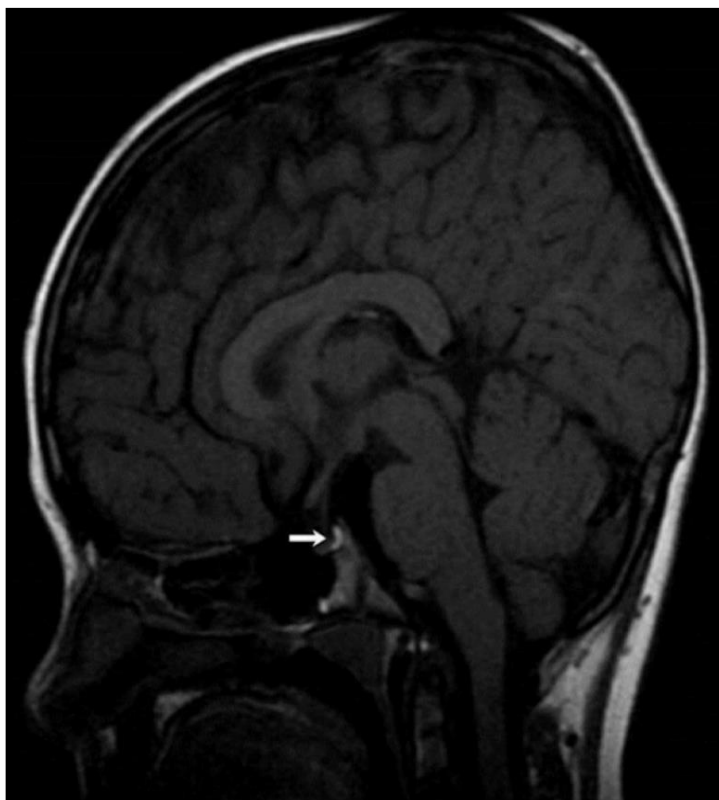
Sagittal T1 weighted Magnetic resonance imaging (MRI) showing a normal anterior pituitary, posterior pituitary and pituitary stalk study.
